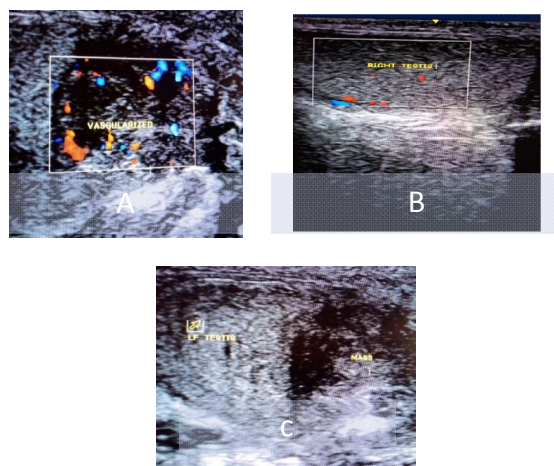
Doppler scan showing (A)- Left testis and mass with increased blood flow, (A) Right testis with normal blood flow. (C) The ultrasound shows a mass on the left scrotum with left atrophic testis
